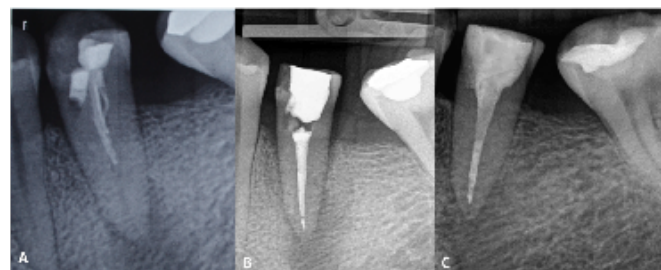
Radiographs of root canal treatment performed with AH Plus at level 3.5. A-baseline B-6 months C-12 months
